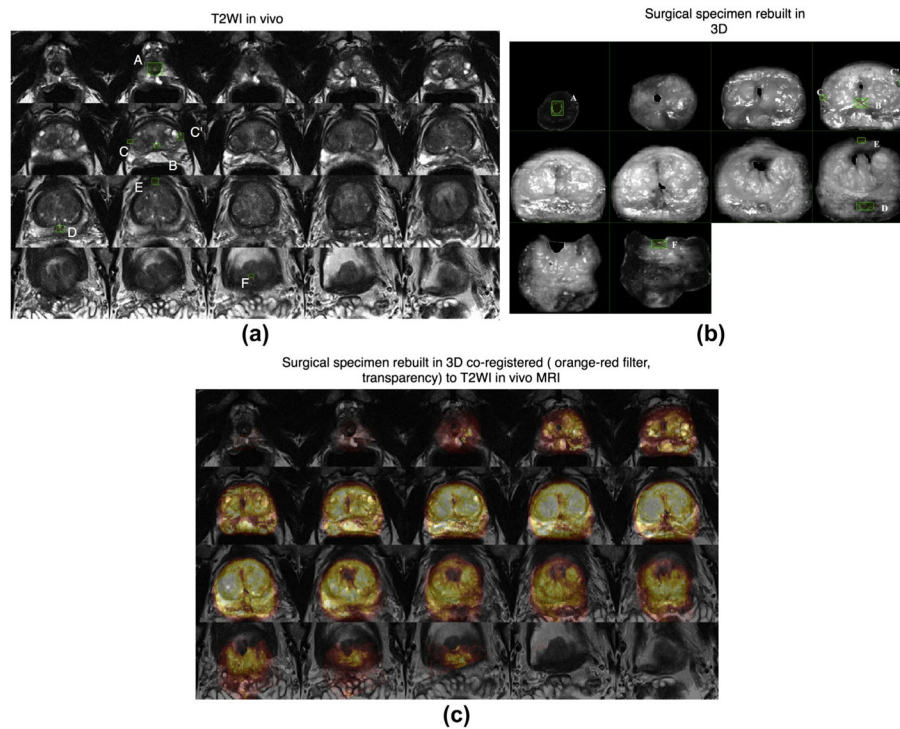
Zonal anatomy landmarks and examples of landmark-based co-registration in 3D. 3D landmarks are in green boxes plotted by an operator and used for transformation computation. The landmarks were A: distal point of urethra at apex; B: veru montanum; C & C': anterior-most point of the right and left peripheral zone horn; D: ejaculatory duct; E: anterior-most point of the gland overall; F: proximal end of urethra at the prostate base, adjacent to the bladder. MRI, magnetic resonance imaging; T2WI, T2-weighted images; 3D, three dimensional. (For interpretation of the references to colour in this figure legend, the reader is referred to the web version of this article.)
